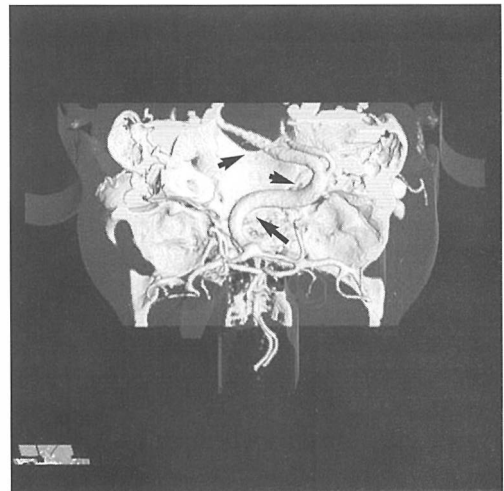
CT angiogram, volume rendering technique, posterosuperior view, demonstrates fusiformly dilated and elongated right vertebral artery and basilar artery (arrows). On the basis of this examination, it was decided that the patient was not an operative candidate. DSA was avoided in this case.
